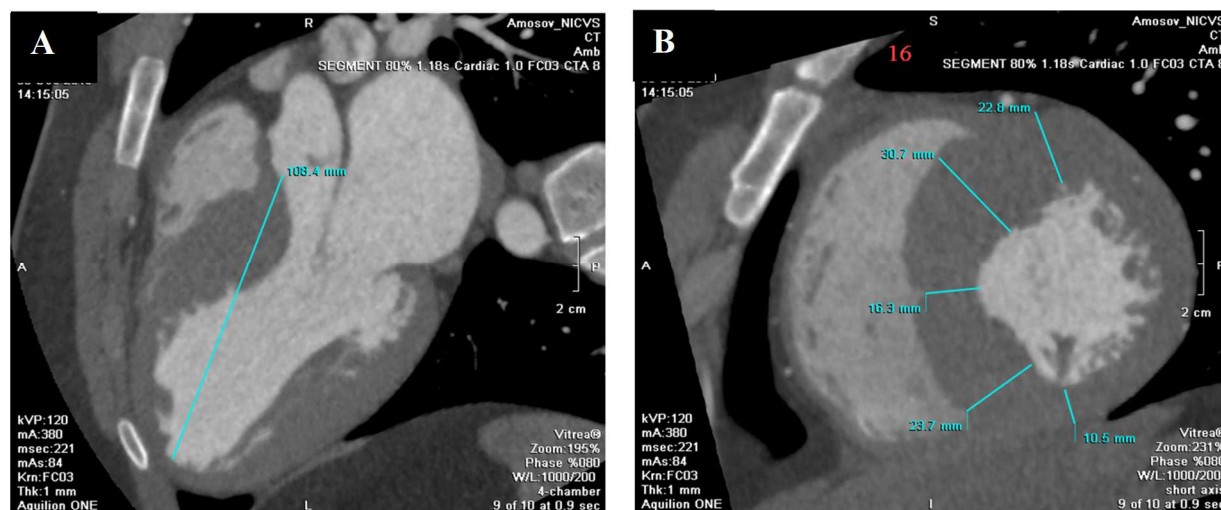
Mandatory preoperative CT planning where the distance from the aortic annulus to the apex of the LV (LV depth) (A) and the dimensions of the LV and IVS at a distance of every 8 mm from the aortic annulus along the short axis are measured (B)
